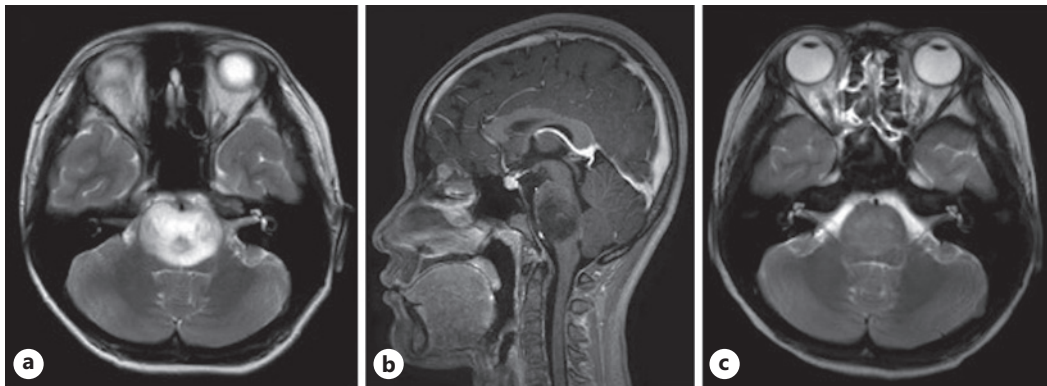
Magnetic resonance image (MRI) of the brain in case 1. a Swollen internal nonuniform high-signal area on T2-weighted image. b Gadolinium (Gd) contrast-enhanced brain MRI model showing poor contrast on T1-weighted image. c Posttreatment MRI showing clear shrinkage of tumor.
